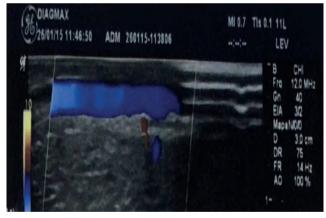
Doppler did not show thrombosis of the dorsal vein of the penis or corpora cavernosa
